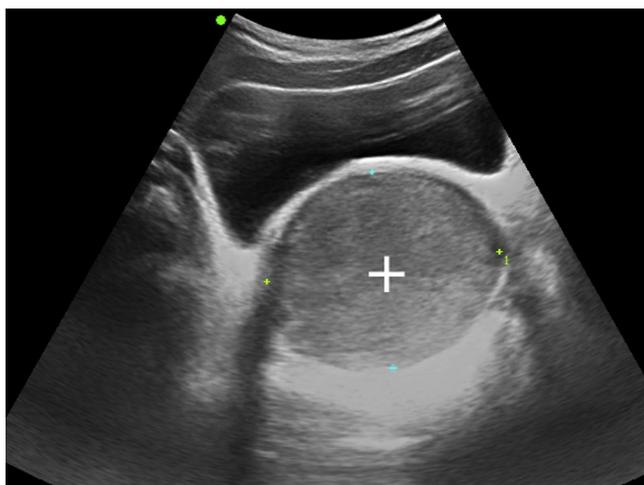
Transabdominal ultrasonographic image showing dilatation of the vagina (plus sign) as a result of fluid accumulation.
